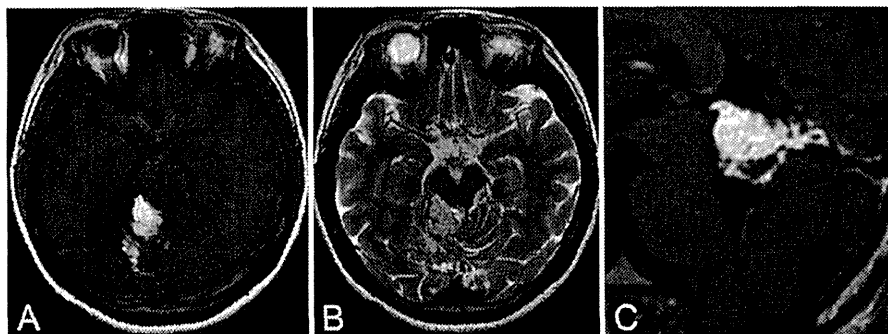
Axial T1-weighted (A), axial T2-weighted (B), and sagittal Gd-enhanced T1-weighted MR images (C) obtained when the patient presented to our institution, showing a high-intensity mass in the supramedial cerebellum that compresses the dorsal midbrain and the upper pons.
